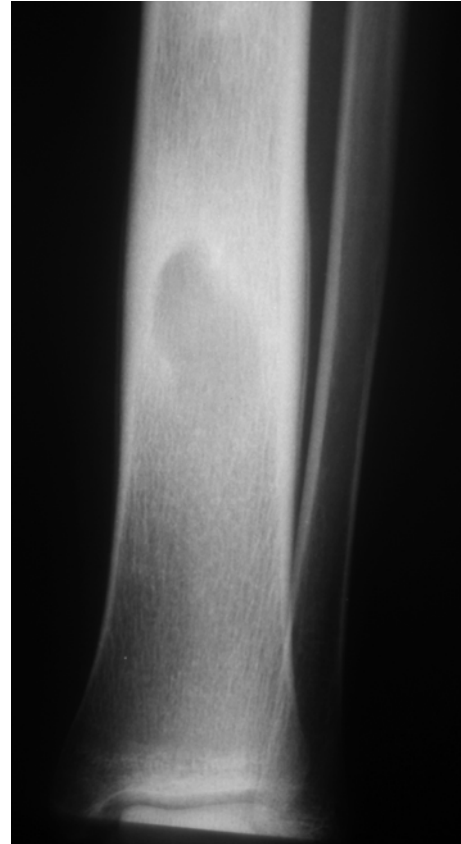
X-ray of an 8-year-old boy with a 6-month history of leg pain
